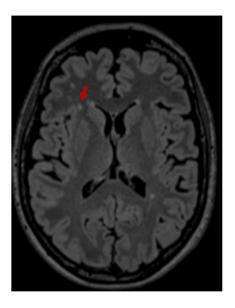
T2-weighted brain MRI from participating patient showing low white matter hyperintensities (WMH) load.
